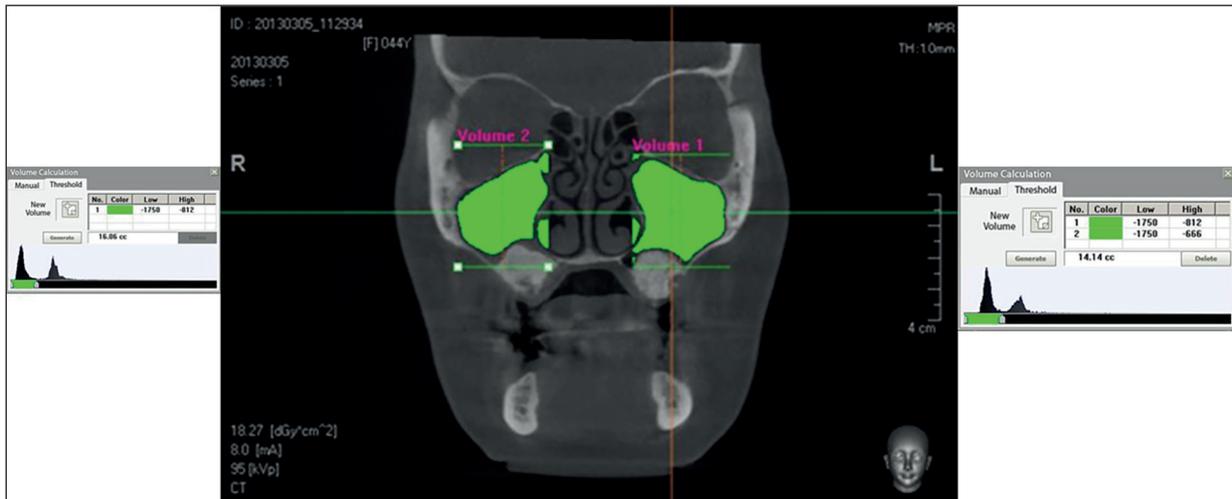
Multislice CT images of the maxillary sinus was obtained by the software Syngo CT 2011 A VOLUME, measuring the total volume of the sinus after sinus lifting.
